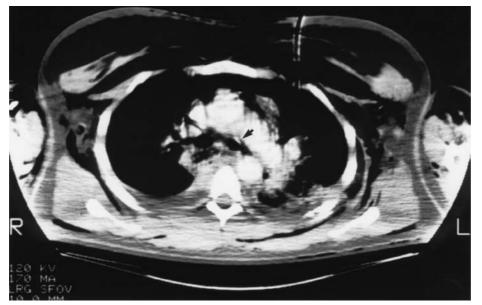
Computed tomography scan at and just below the carina showing a separated left main bronchus following blunt chest trauma (arrow). Massive emphysema is seen in all layers of the chest wall.
